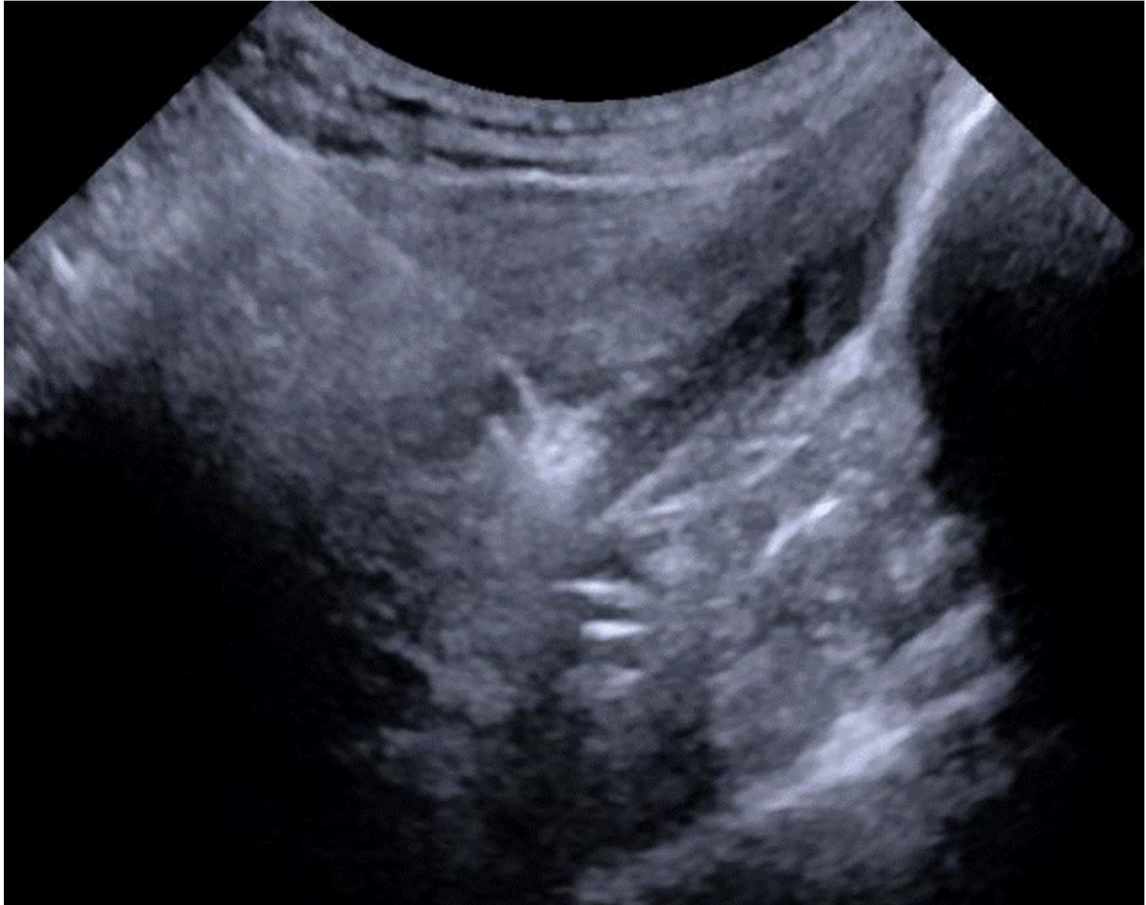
Ultrasound-guided botulinum toxin injection into the right piriformis muscle.
